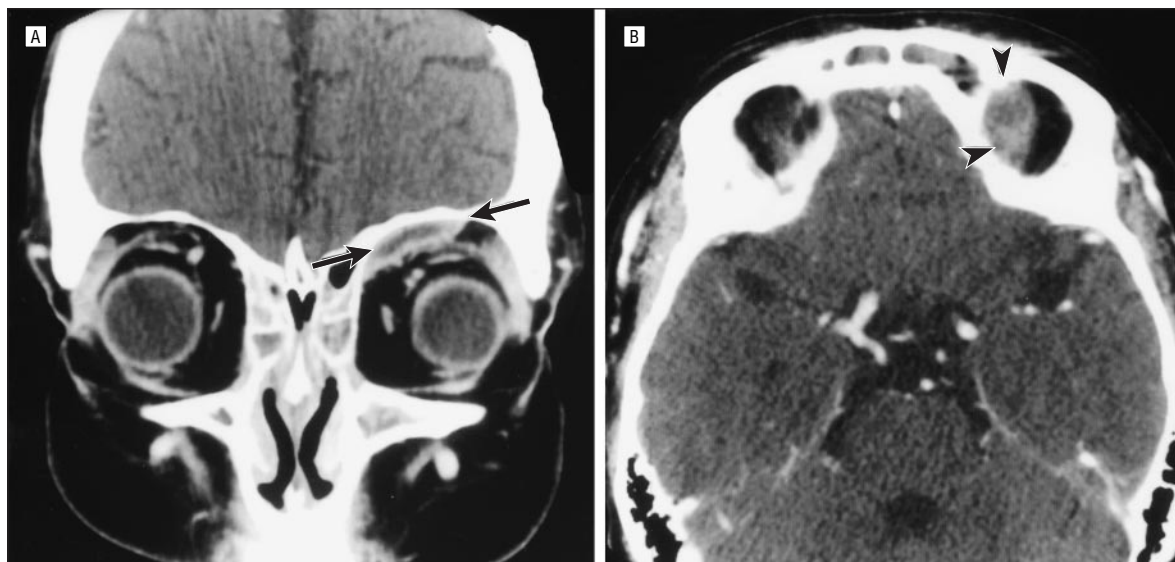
Enhanced computed tomography images reveal the left superior medial orbital mass. A, Coronal computed tomography image shows the left extraconal, marginally enhancing mass (arrows). B, An axial computed tomography image also demonstrates the superior orbital mass (arrowheads).
